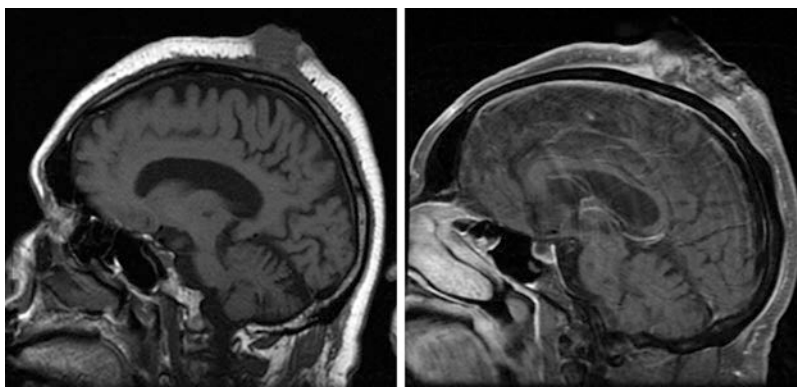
Left:* Sagittal T1 noncontrast MR image of the brain. The subtle *gray line* over the hyperintense subcutaneous fat represents normal skin. The angiosarcoma involves the skin and galea aponeurotica and demonstrates signal iso-intense to muscle [39]. *Right:* sagittal post-contrast fat-saturated T1 image of the brain. The
